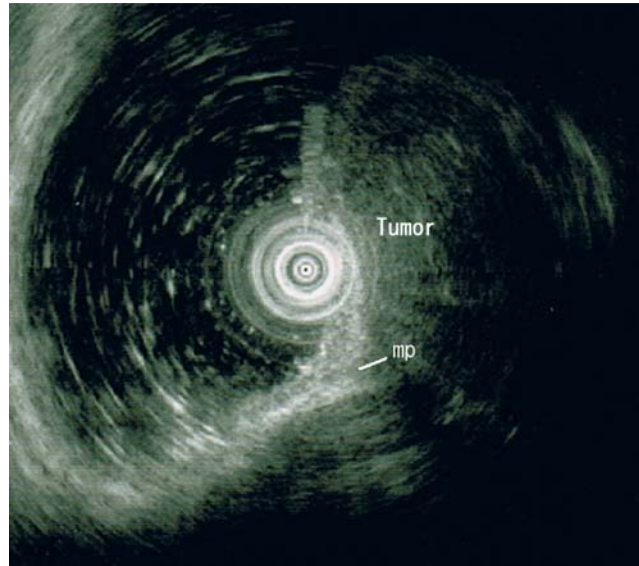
Endoscopic ultrasonography showing a homogeneous, hypoechoic tumor derived from the muscularis propria (mp).
